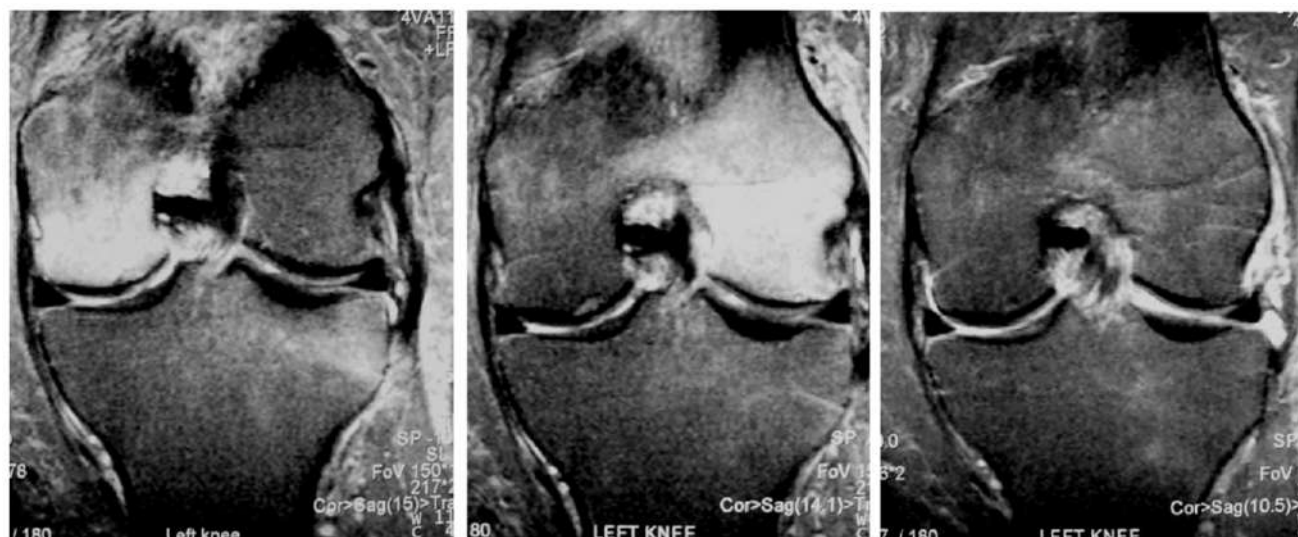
A migratory form of ITO with initial presentation and MRI features showing medial femoral condyle involvement, then 4 months later migration to the opposite condyle and then 6 months total resolution of all symptoms and finds.
